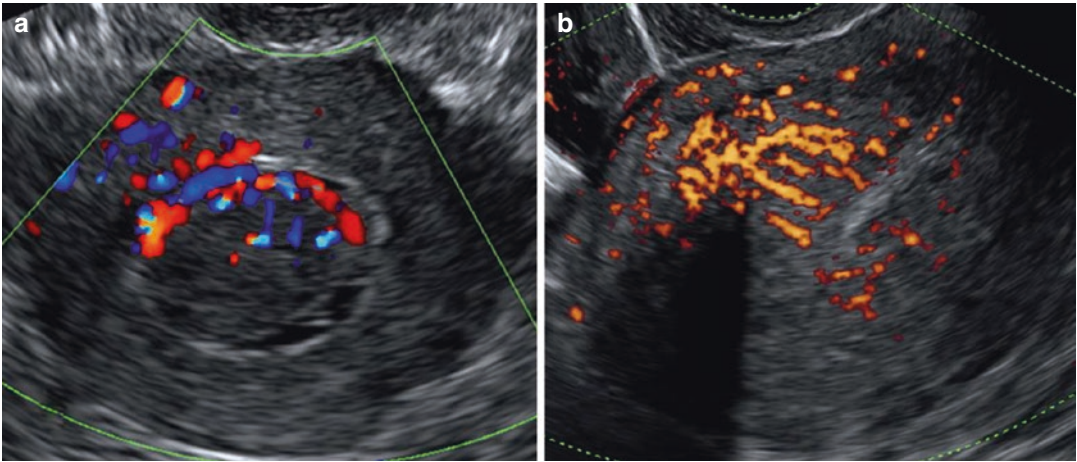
Ultrasound image of a fibroid with circumferential flow (a) and adenomyosis with translesional flow (b)
